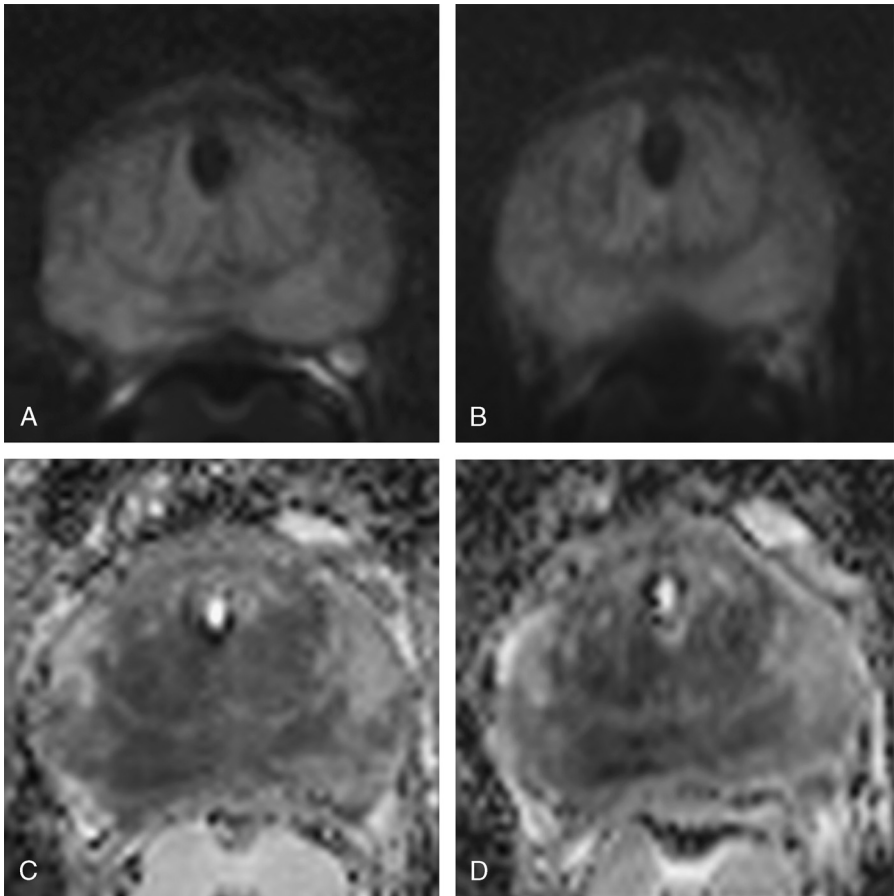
A 60-year-old male patient undergoing mpMRI of the prostate. Rs-DWI b=1000 slice (A), reduced-FOV sTX-DWI b=1000 slice (B), rs-DWI ADC map (C), and reduced-FOV sTX-DWI ADC map (D) are shown. Both sequences (including ADC maps) were rated above average by reader 1 and excellent by reader 2 in overall image quality.
